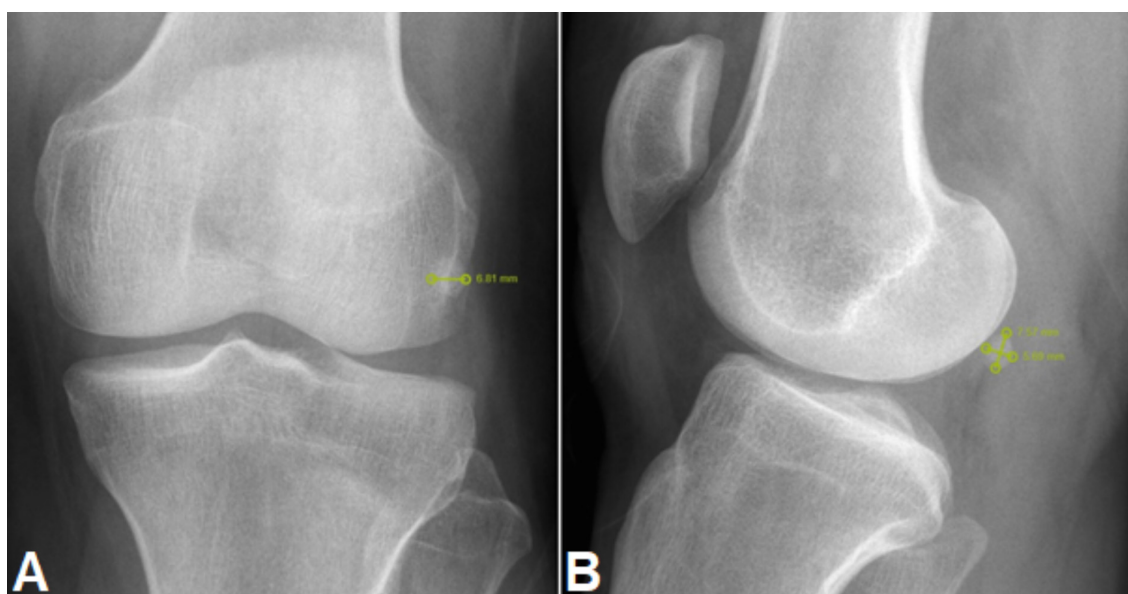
Morphometric measurements on direct X-rays. A, Anteroposterior X-ray. B, Lateral X-ray.
